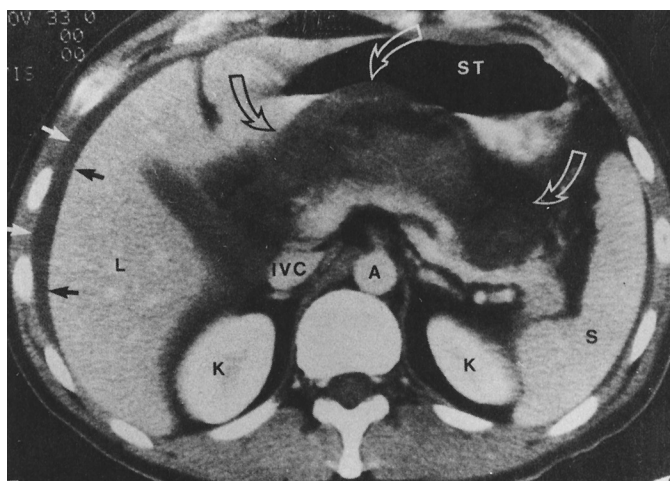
Acute pancreatitis. Computed tomographic (CT) scan through the body of the pancreas demonstrates a halo of decreased attenuation around the pancreas that represents a peripancreatic zone of edema and fluid (curved arrows). Note the pancreatic ascites, most obvious lateral to the liver (small arrows). If intravenous contrast were administered before the CT scan, the inflamed pancreas would appear more dense (whiter). A, aorta; IVC, inferior vena cava; K, kidney; L, liver; PV, portal vein; S, spleen; ST, stomach. (From Freeny P, Lawson T. In: Putman CE, Ravin CE, eds. *Textbook of Diagnostic Imaging*. Philadelphia: WB Saunders; 1988.)
